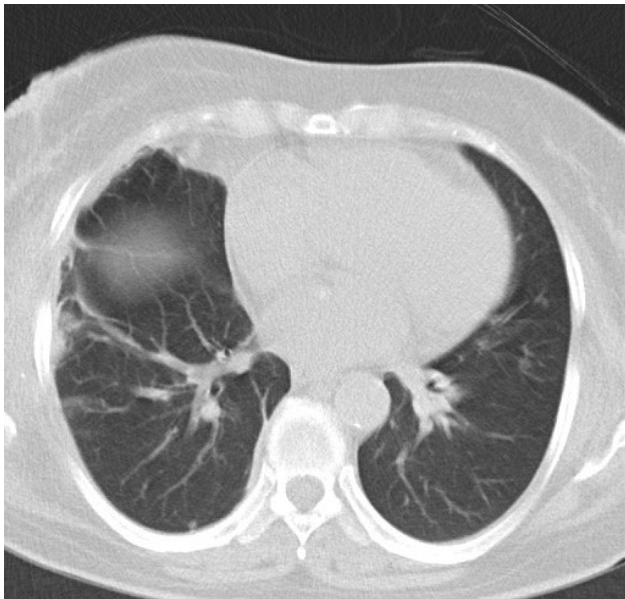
The spiral CT scan of the thorax after thoracotomy to clear the cysts in the right lung
